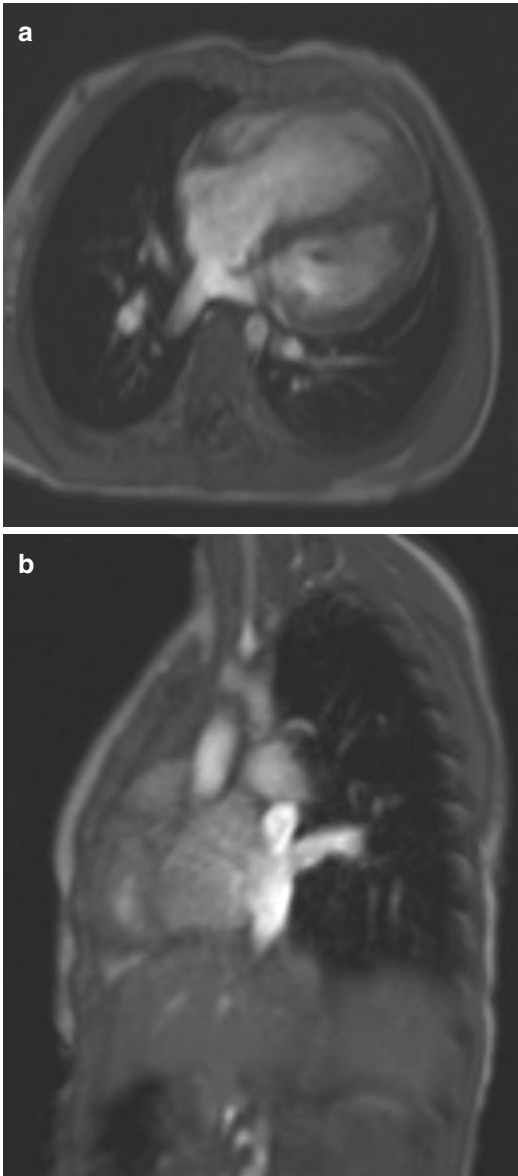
Inferior sinus venosus atrial septal defect. (a) Four-chamber view image obtained from cine FLASH MRI sequence shows a communication between the posterior aspect of inferior vena cava and the left atrium. Blood from the right inferior pulmonary vein is directed into the inferior vena cava/right atrium instead of the left atrium. The QP/QS ratio was 2.8:1. (b) Sagittal oblique view image obtained from cine FLASH MRI sequence demonstrates the right inferior pulmonary vein draining into the right atrium near the opening of inferior vena cava
